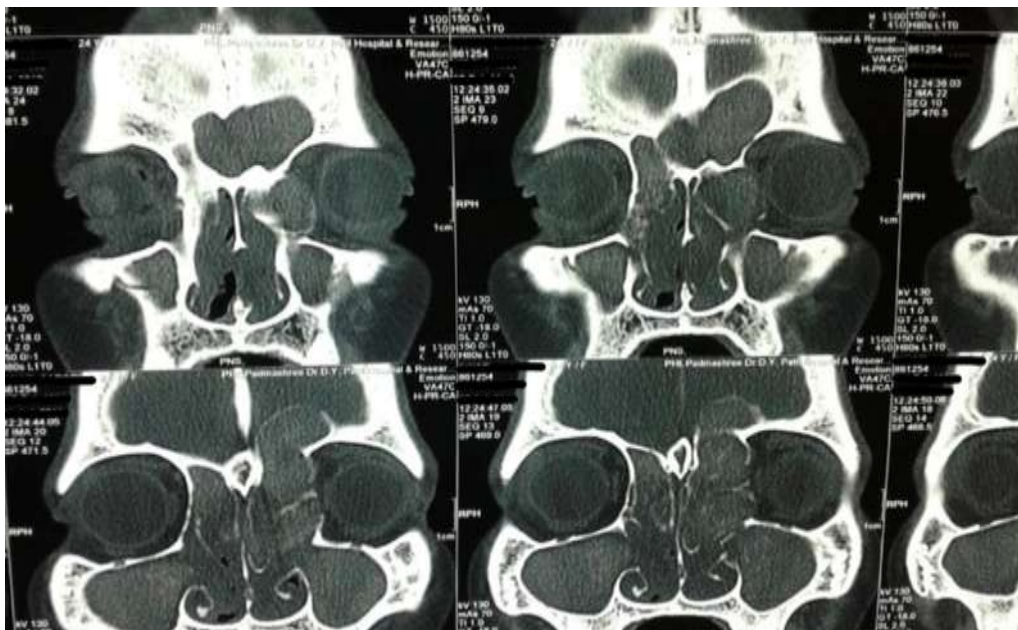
Pre-Operative CT Scan Of The Paranasal Sinus Showing Huge Left Frontoethmoid Mucocele
